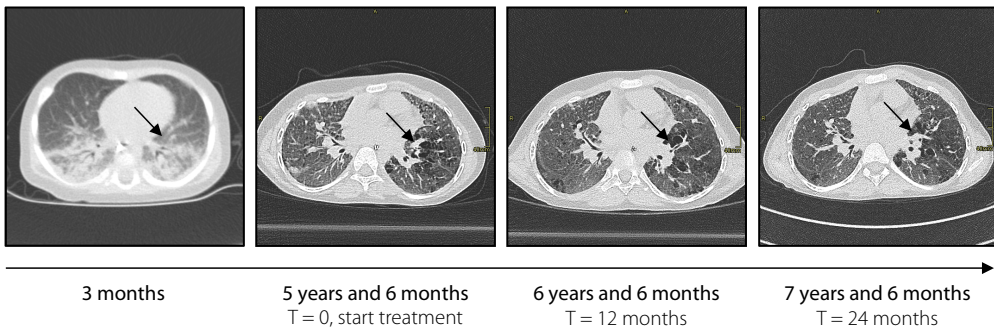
high-resolution computed tomography (HRCT) chest scans of *PIARS*.
